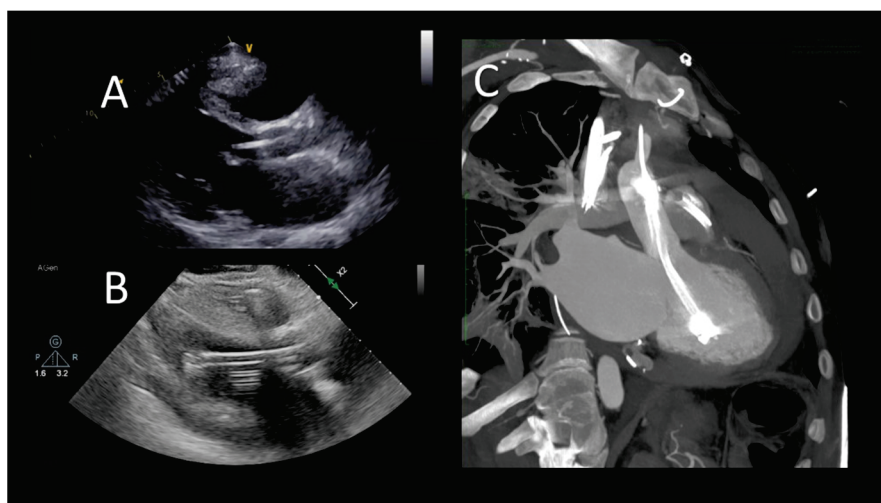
Transthoracic echocardiographic evaluation after Impella implantation (A) device's correct position; (B) incorrect position (towards the left ventricle apex), (C) cardiac computed tomography showing incorrect, apical position.
